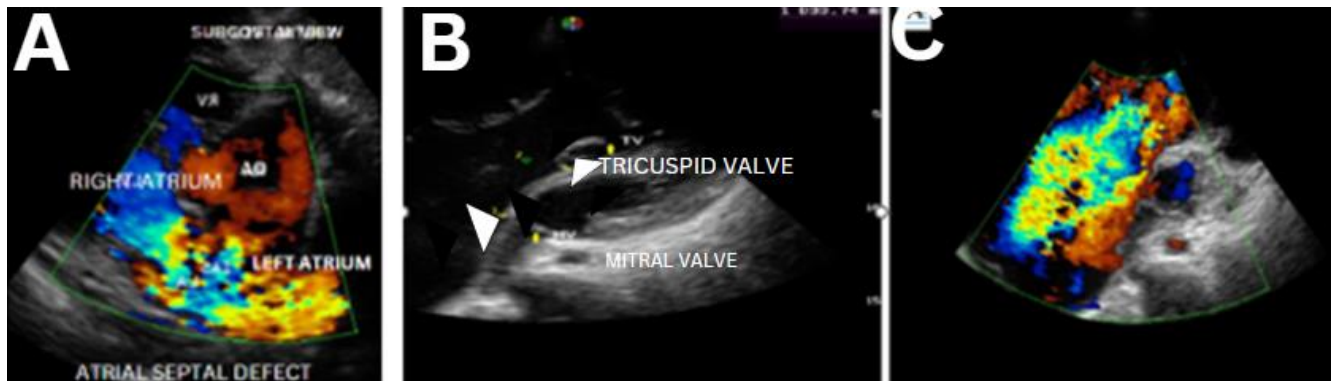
An Echocardiogram of an Ostium secundum type Atrial Septal Defect. B. Pel Epstein Anomaly. C. Color Flow showing severe TR Jets in Pel Epstein Anomaly.
